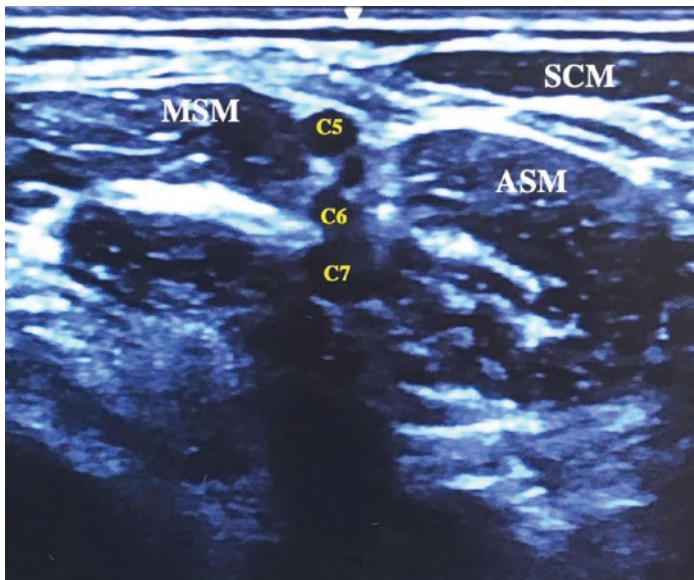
Interscalene nerve block ultrasound
